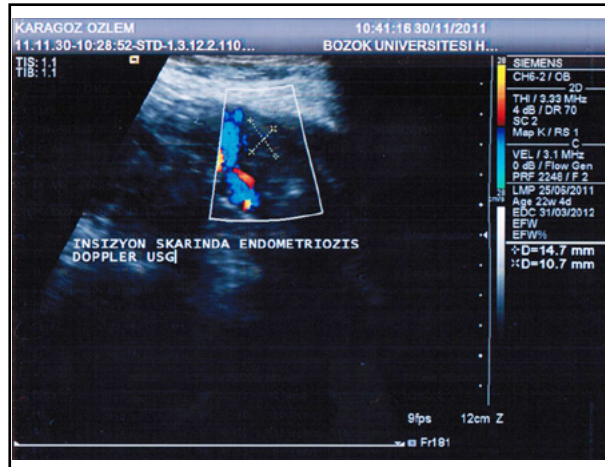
Demonstration of endometriosis located on incisional scar tissue by Doppler ultrasound.
